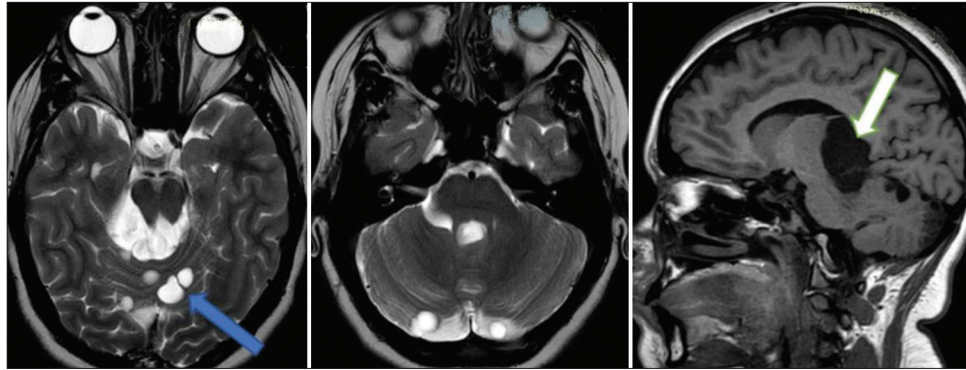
MRI 1 year after surgery showed cystic lesions in the operative corridor (blue arrow) and an enlarging pineal region cyst with its contents slightly more hyperintense to CSF on T1 (white arrow).
